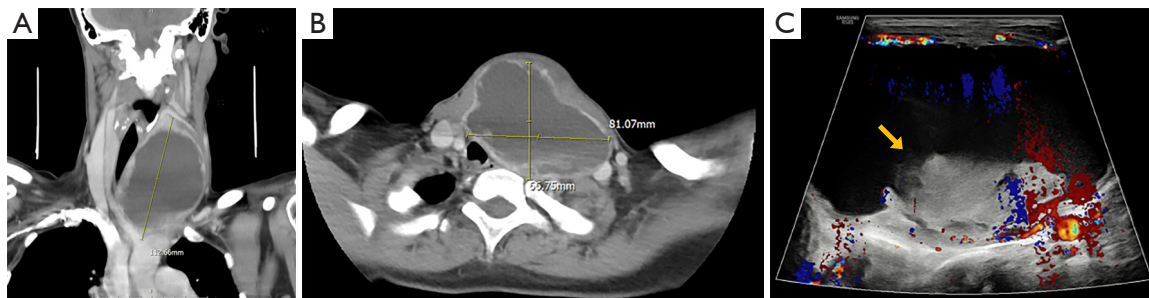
Radiologic findings after the operation. (A) Coronal CT scan of the neck; (B) axial CT scan of the neck; (C) thyroid ultrasonography. A re-enlarged cyst was revealed by the CT scan of the neck after the operation (A), which was probably hemorrhagic. The neck CT scan revealed that the trachea was deviated to the right by the thyroid cyst (B). In thyroid ultrasonography on postoperative day 1, an echogenic mass (yellow arrow) presumed to be a blood clot was in the lower wall of the cyst (C). CT, computed tomography.
